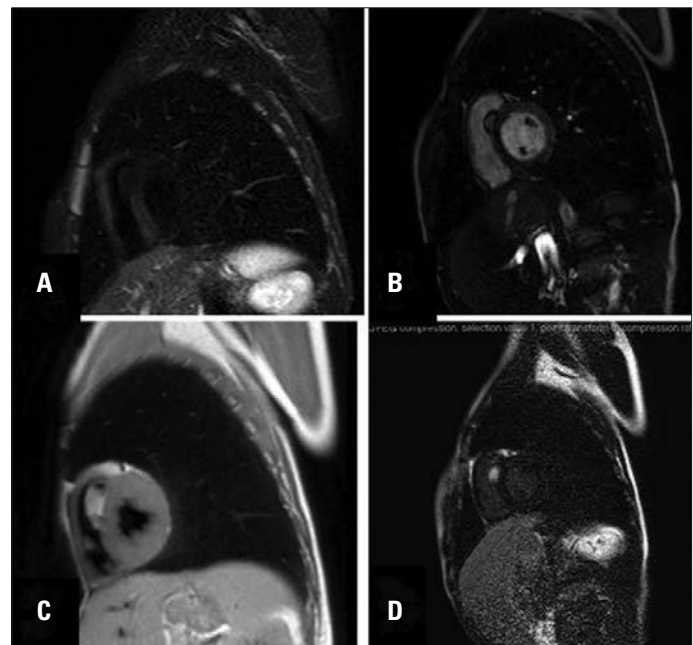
Magnetic resonance imaging of right ventricular lipoma
